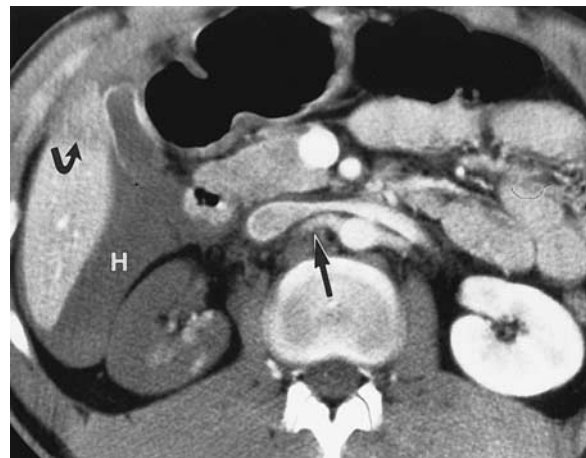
Traumatic occlusion of the main renal artery (category III) in a 38-year-old man who had sustained blunt abdominal trauma. Contrast-enhanced helical CT scan demonstrates a diminished right nephrogram. The proximal right renal artery (straight arrow) is enhanced; however, the distal main renal artery is not visualized. Note also the hepatic laceration (curved arrow) and hemoperitoneum in the Morrison pouch (H).
